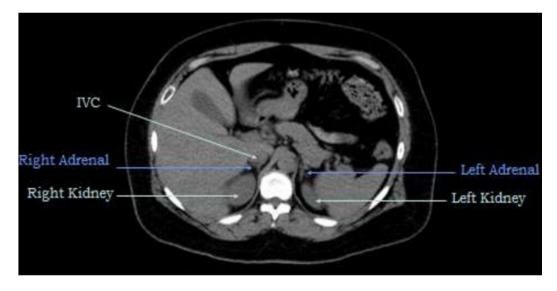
(Normal CT abdomen)
